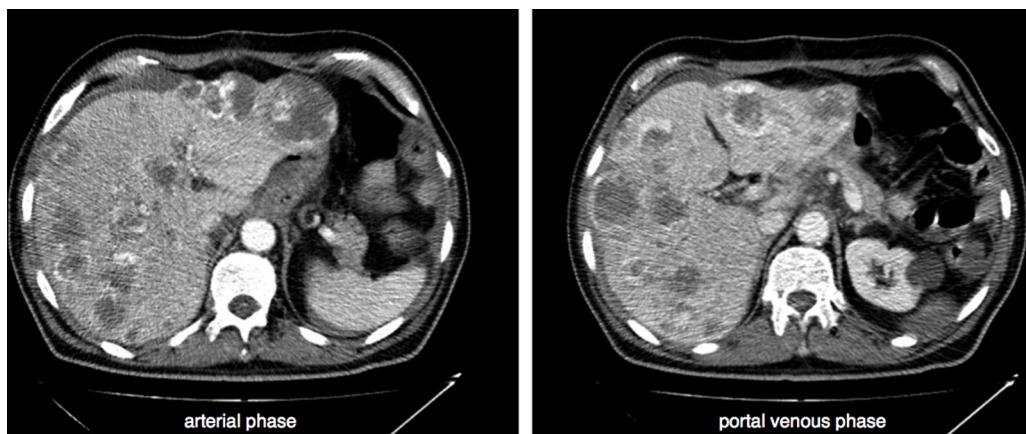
Contrast-enhanced CT scan of abdomen taken in arterial and portal venous phases showed hypervascular liver metastases with signs of active bleeding from subcapsular lesions, causing hemoperitoneum.
